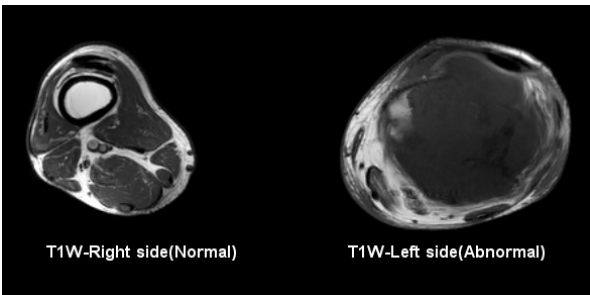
MRI- T1W axial image
